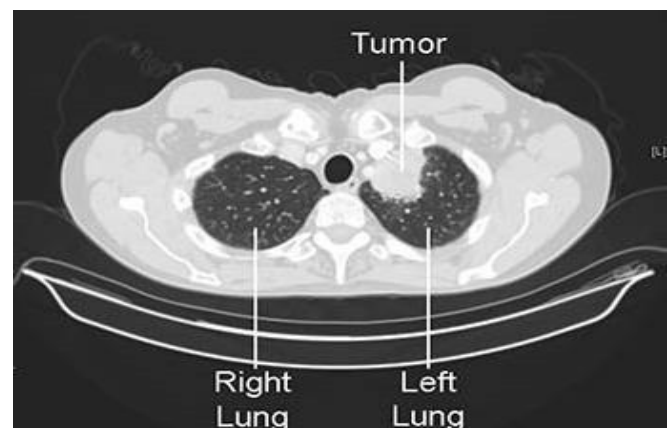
Lung CT Scan Image [1]
